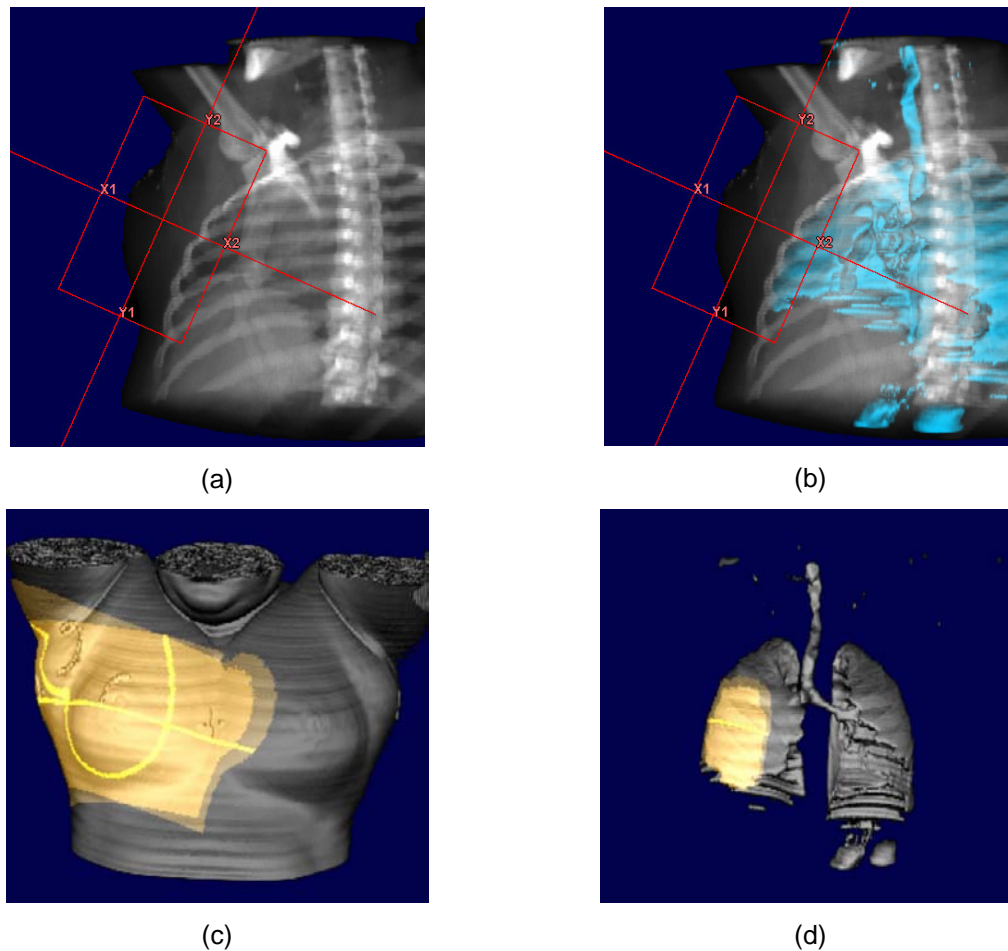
BEV reconstruction of a patient with neck carcinoma. On the left image the standard volume rendering techniques are used to render the CT volume and the segmented organs. On the right side the low contrast volume of the trachea and lungs is automatically extracted using the RG methods and rendered using the image blending method. On the lower row the BEV is reconstructed from the anterior view lack of volumes of interest.
